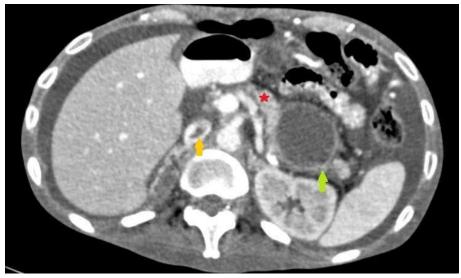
CT axial section showing infrahepatic part of IVC showing hypodense filling defect suggestive of thrombosis (yellow arrow) and thin-walled cyst in tail of pancreas (green arrow)
